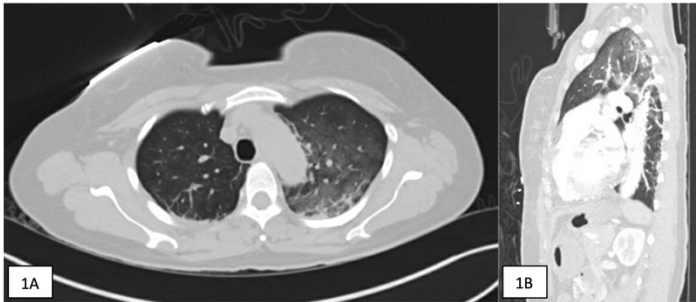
Computed tomography of the thorax (Figure 1A: Axial plane; Figure 1B: Sagittal plane), showing patchy consolidation and septal thickening in the left upper lobe, reported as mild lung contusion and hemorrhage.
